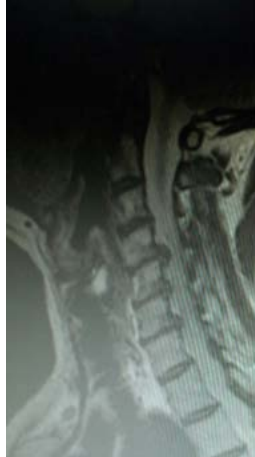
Preoperative sagittal magnetic resonance imaging of C4-5, C5-6, and C6-7 level HNP, osteophyte, and osteophyte.
